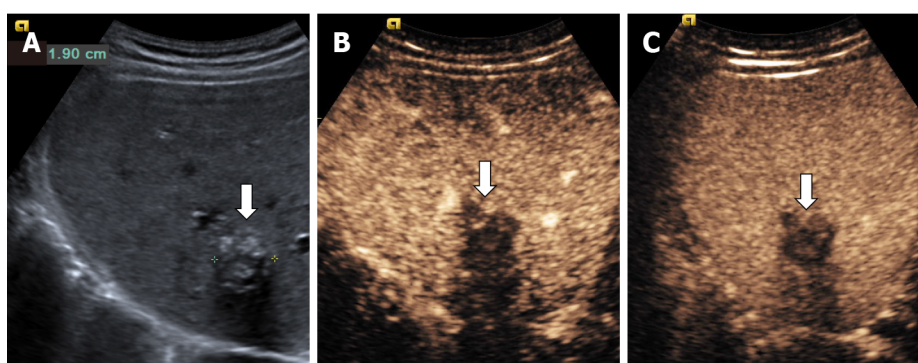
Hemangioma with calcifications in a 64-yr-old man detected on a routine ultrasound examination. A: On B-mode ultrasound several spotted calcifications are showed in the marginal and central part of the lesion and posterior acoustic shadow also; B and C: On post-contrast administration no enhanced is noticed in the portal (B) or the late phase (C).
